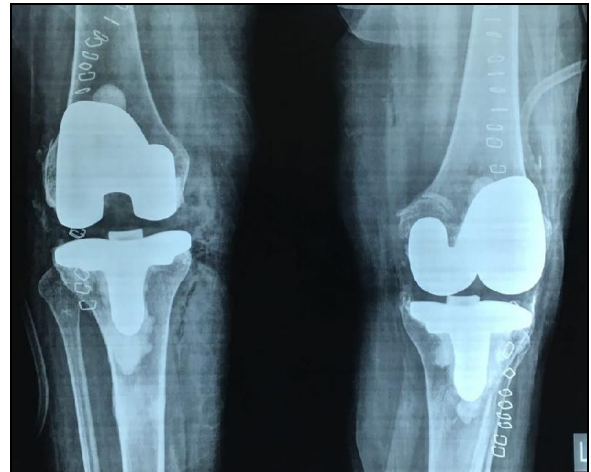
Post-operative x-ray AP view of both knee joints
